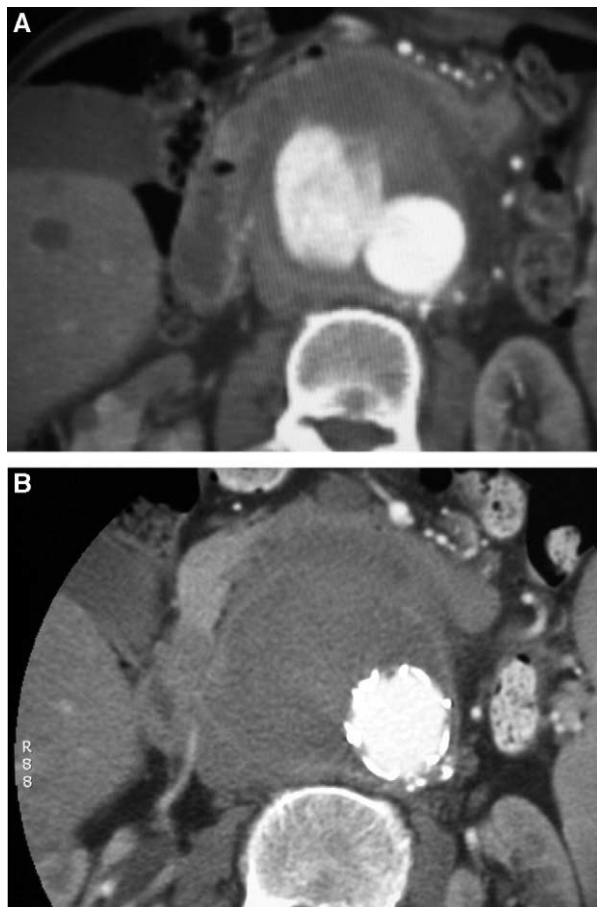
A, Contrast computed tomography (CT) demonstrating sac enlargement (9-cm diameter) 15 years after open abdominal aortic aneurysm repair due to a defect in the mid portion of the body of the bifurcated graft implanted at previous open repair. B, Contrast CT confirming exclusion of the recurrent aneurysm sac from the circulation after endovascular repair.
